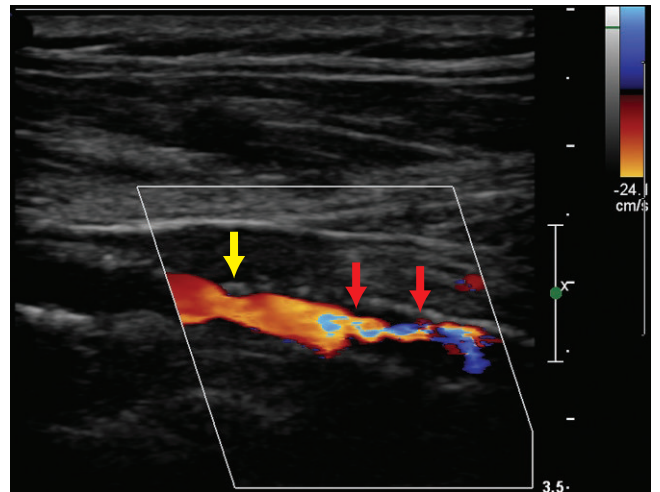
Color Doppler of the area of interest is optimized to show the narrowing of the popliteal artery. In a milder stenosis there is no change in color (yellow arrow). In the region of greater narrowing measured on Figure S23-2 there is narrowing and aliasing (red arrows) with a mixture of colors.
